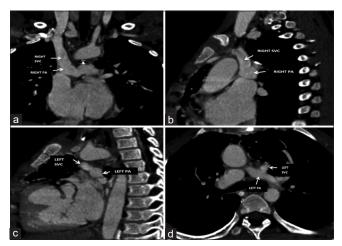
Double superior vena cava. (a) coronal and (b) sagittal computed tomography (CT) pulmonary angiogram images showing right superior vena cava draining into right pulmonary artery, (c) sagittal and (d) axial CT pulmonary angiogram images showing left superior vena cava draining into the left pulmonary artery
